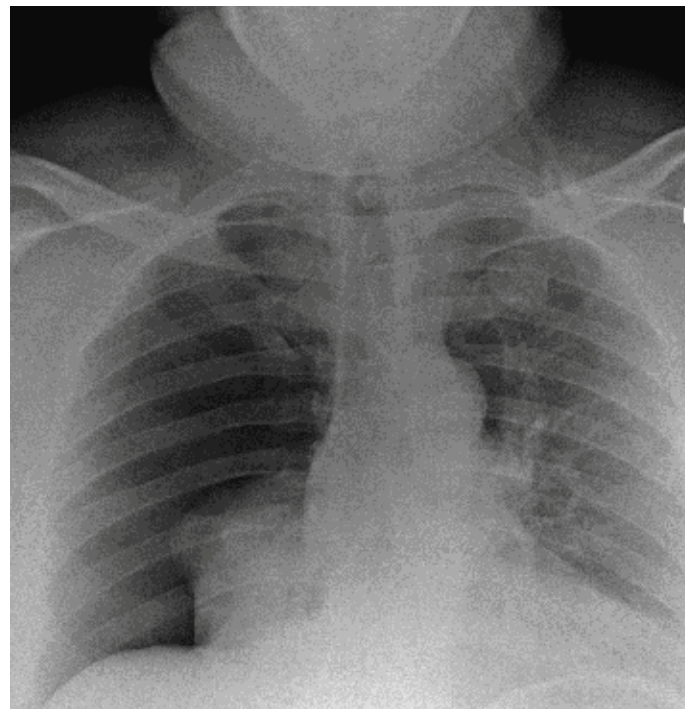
Chest x-ray shows right pneumothorax after right-sided PN.
